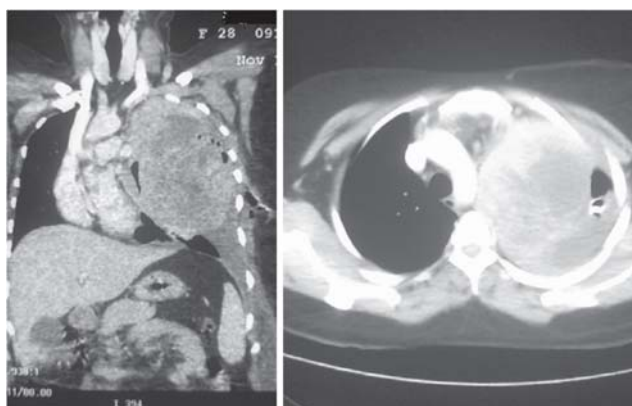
Computed tomography of chest showing a large heterogeneous mass involving left lung with few air loculi within and shifting of mediastinal structures to the right side.
